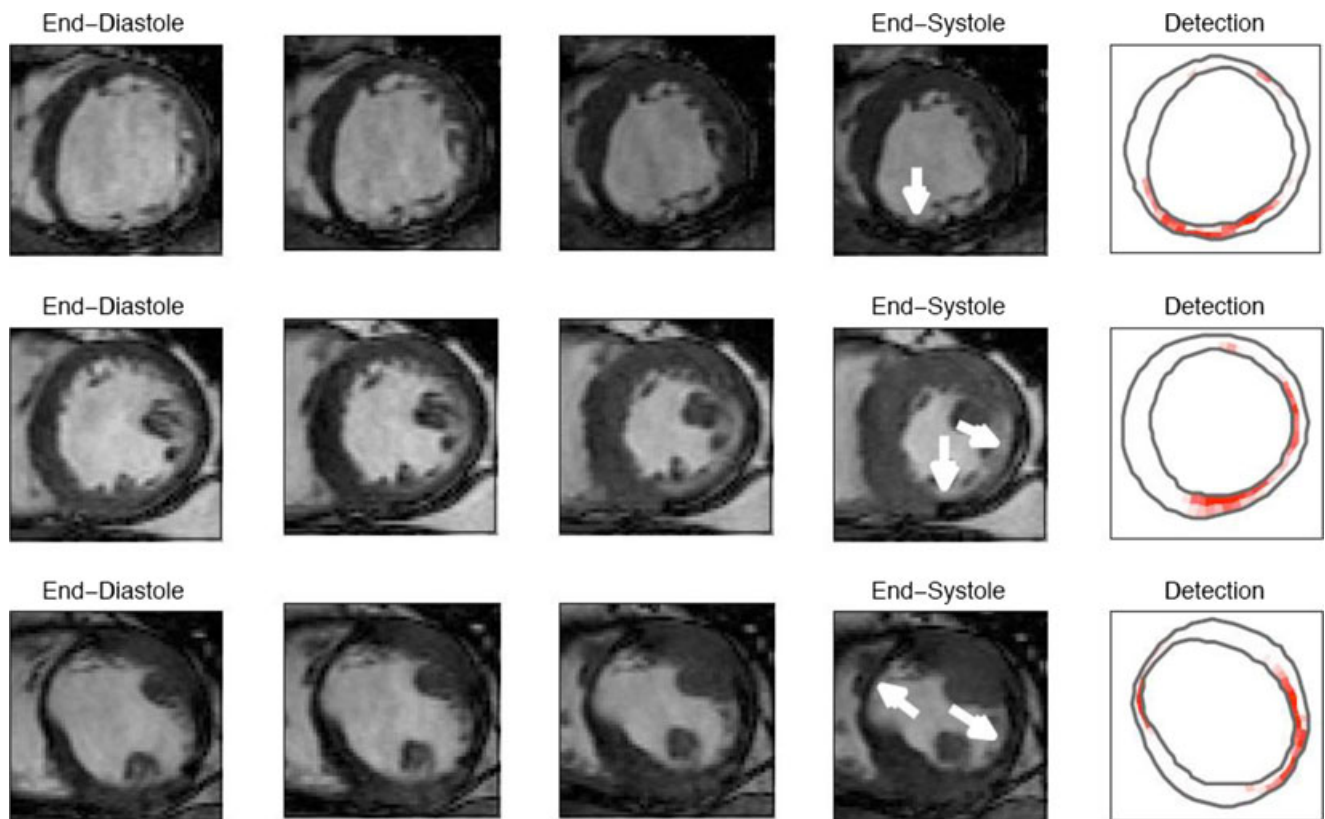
Three automated detection results (right panels) compared with the associated myocardial motion taken from MR image sequences (four frames from end-diastole to end-systole)
